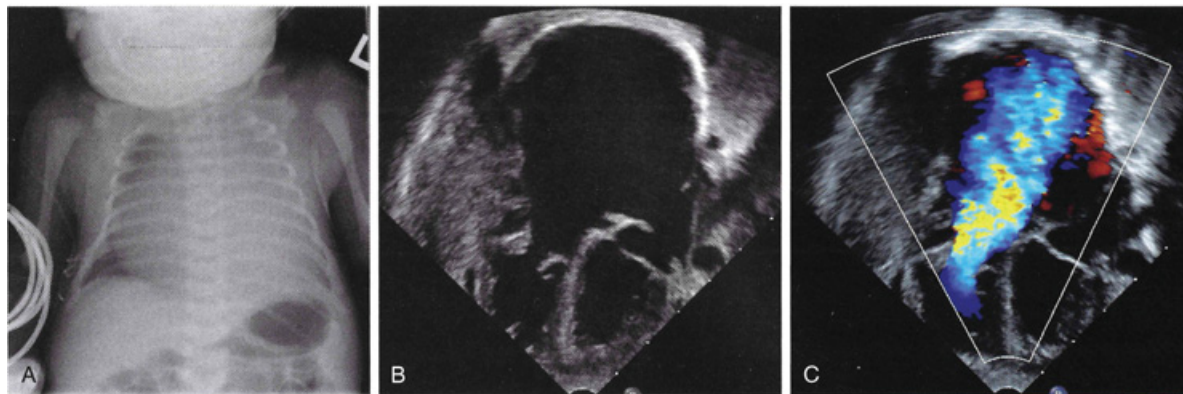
Ebstein anomaly in a neonate. (A) Chest plain film showing marked cardiomegaly. (B, C) Echocardiogram four-chamber view showing a severely dilated right atrium, a secundum atrial septal defect, and severe tricuspid regurgitation. From Kussman B., et al. Congenital cardiac anesthesia. Non bypass procedures. In Davis P. J. and Cladis F. P., eds. *Smith's Anesthesia for Infants and Children*, 9th ed. Elsevier; 2017: 699–743. With permission.
